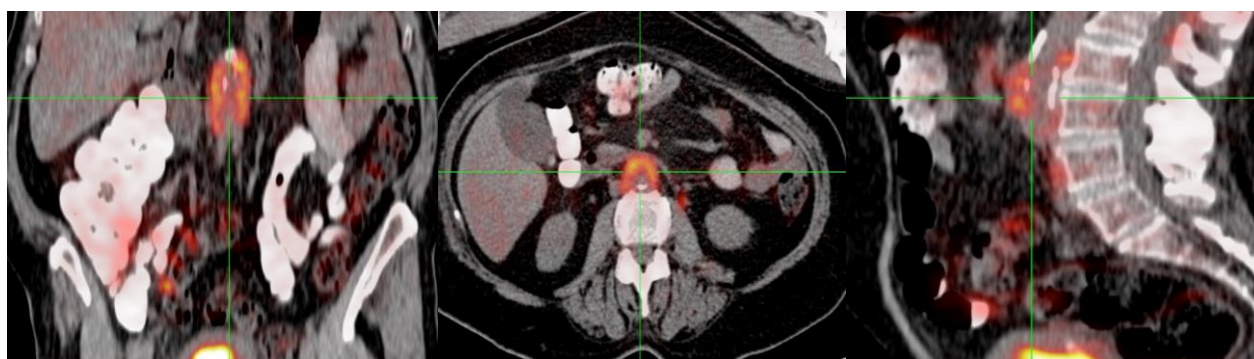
Fifty-seven years old male with suspicious lesions around the thoracic vertebra bodies: metabolic characterization by the PET/CT imaging showed increased FDG accumulations at these lesions as well as abdominal aorta vasculitis.
